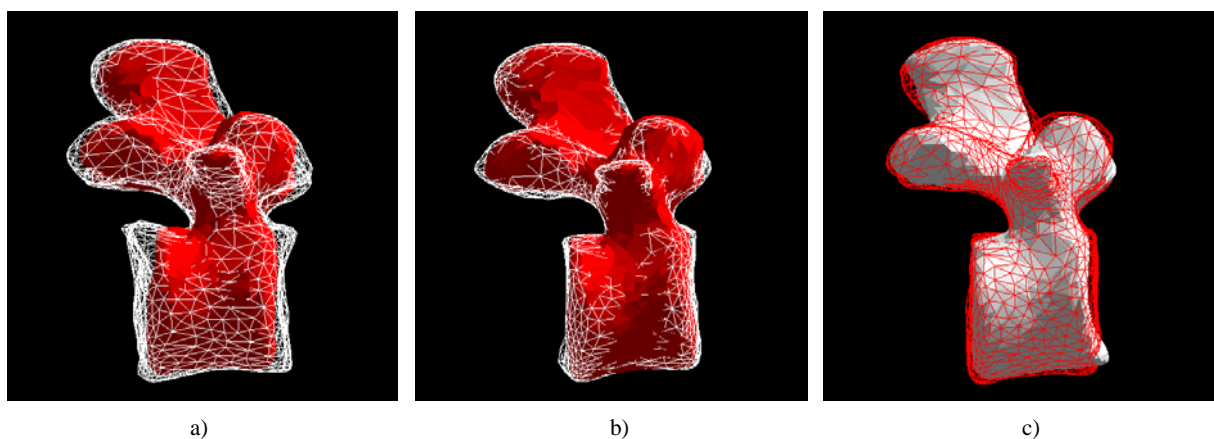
The influence of different bone thresholds on the resulting model. The mesh represents the registered model, the solid model represents the manually segmented CT model for comparison : (a) too low threshold , (b) optimal threshold , (c) too high threshold.
